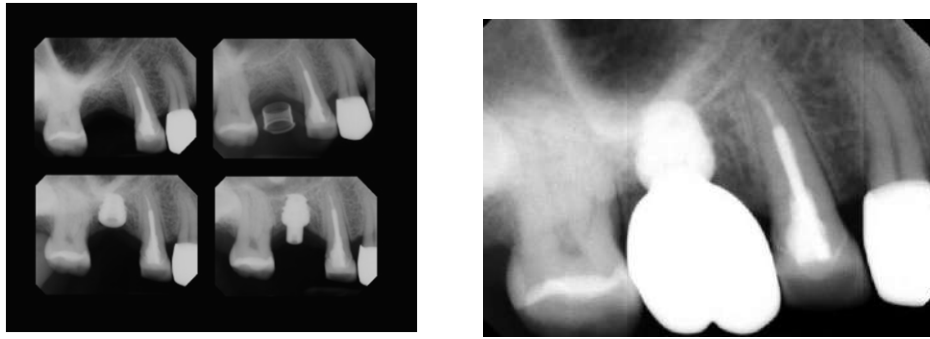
Serial intraoral periapical radiograph with the guide in place and after implant delivery
